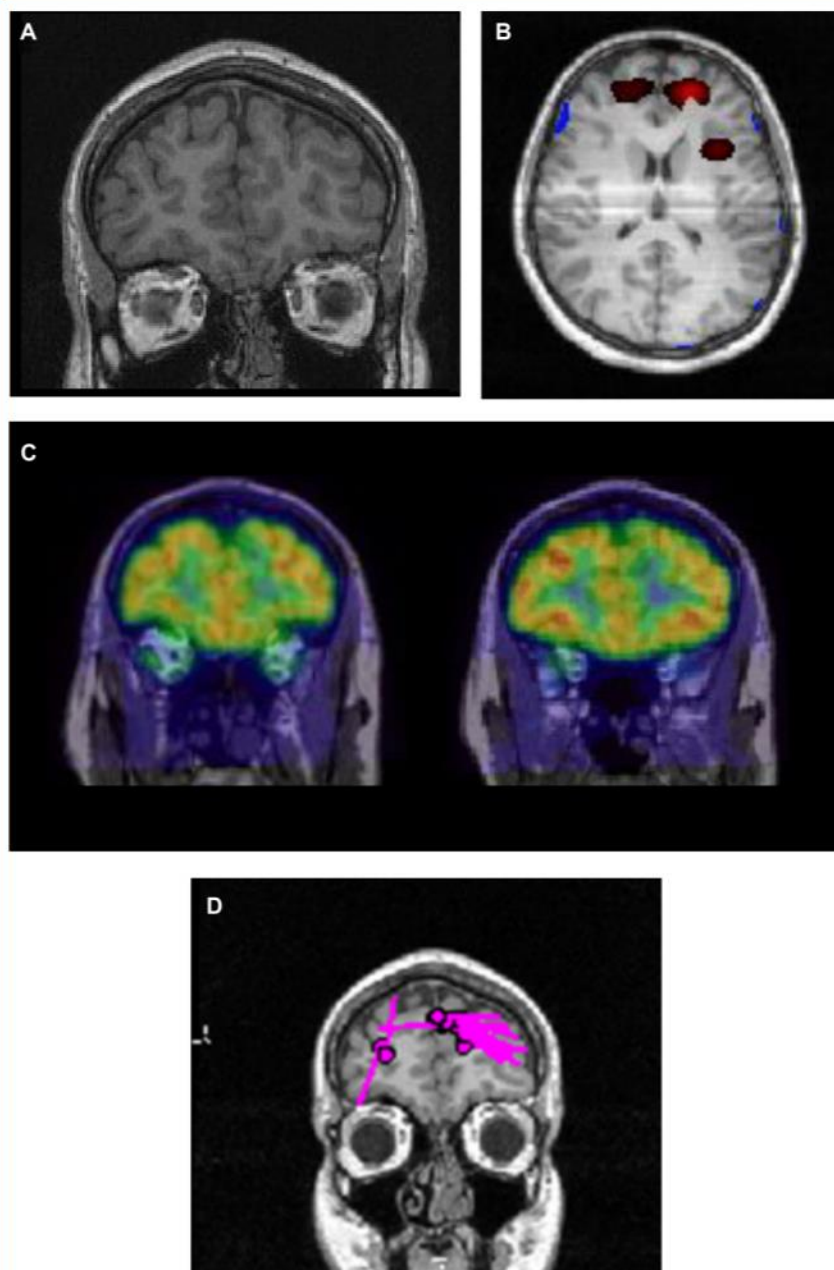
Left rostral frontal seizure localization supported by non-invasive testing. A. MR image (Coronal T1, rostral slice) demonstrating the absence of an identifiable lesion. B. Ictal-SPECT image depicting focal hyper-perfusion in the left frontal rostral region. C. FDG-PET showing focal hypometabolism in the left frontal region. D. MEG scan showing focal discharges in the left frontal rostral region, in corresponding topography with the ictal-SPECT and PET scans.
